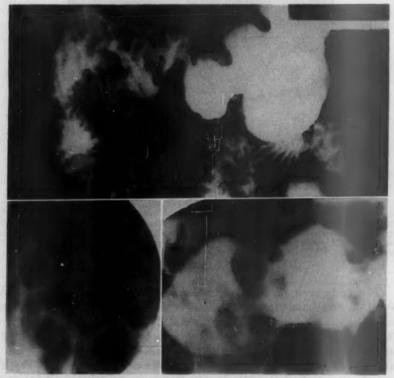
Severe duodenitis in a 20 year old sailor. At age 16 he had acute, painless, massive hematemesis with a negative gastrointestinal series. For three months prior to the above x-rays he had suffered from "sticking" postprandial epigastric pain, nausea and occasional emesis. Note the marked polypoid change in the mucosa of the bulb, with thickening of mucosal folds extending into the second portion of the duodenum. The lower frames are spot films of the duodenal bulb, with and without compression.
